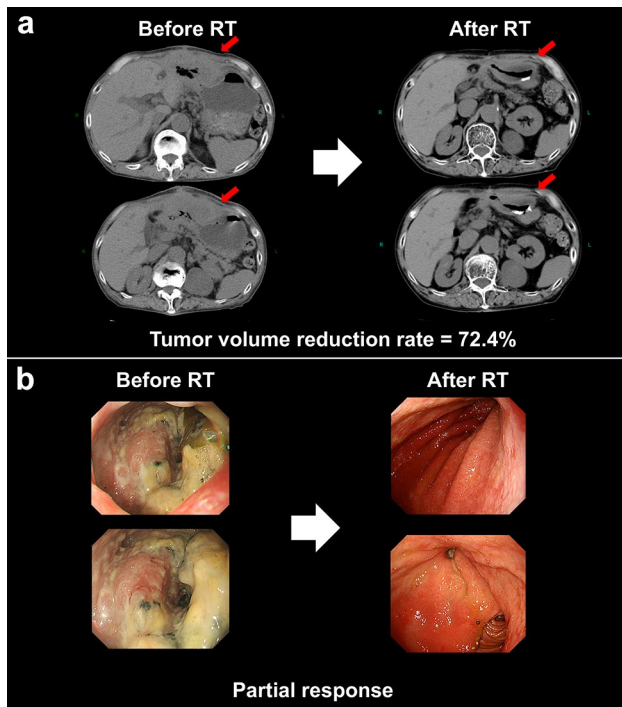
Representative images from the patient with treatment response to RT. Patient G717 was treated with six cycles of nivolumab for stable disease and then received RT for the primary tumor to palliate the symptom of anemia. After RT, the tumor elicited response on both CT scan (a) and endoscopic examination (b), and the patient was relieved of the symptom of anemia
